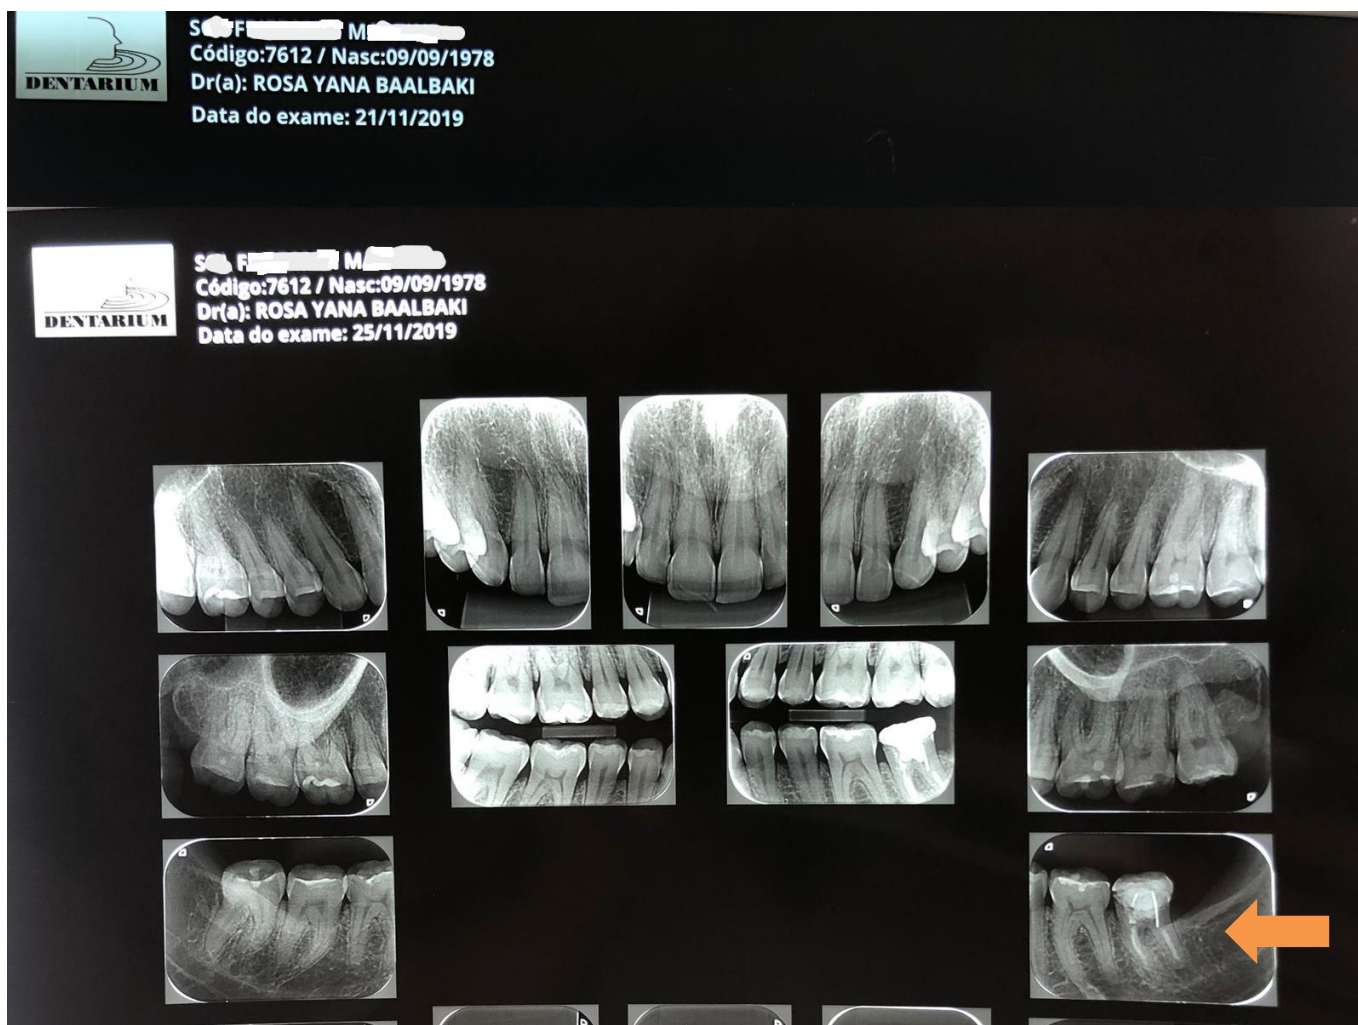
Panoramic X-ray of Patient SFM
